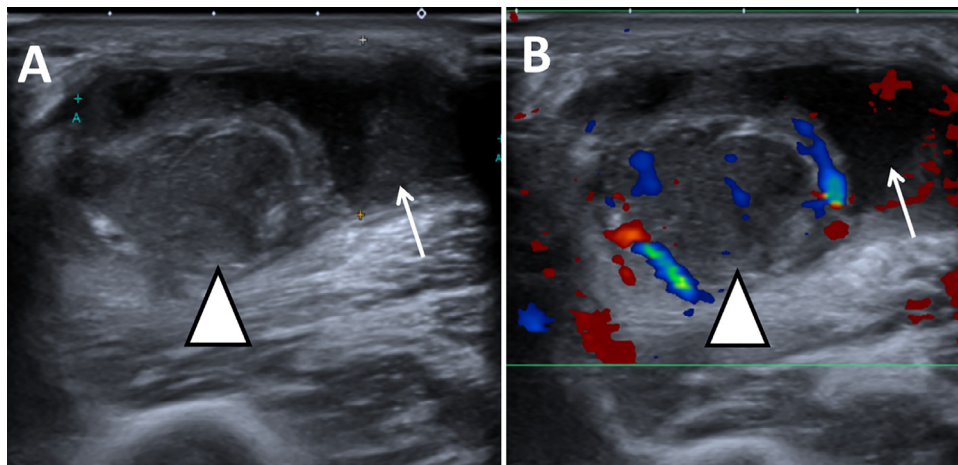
Transverse grey-scale (A) and color Doppler sonographic (B) images. (A) Grey-scale ultrasound image shows thickened ulnar nerve measuring 1.1 cm in diameter (arrowhead). There is fluid surrounding the thickened nerve (arrow). (B) Color Doppler image of the transverse section of the thickened ulnar nerve shows increased vascularity (arrowhead).
